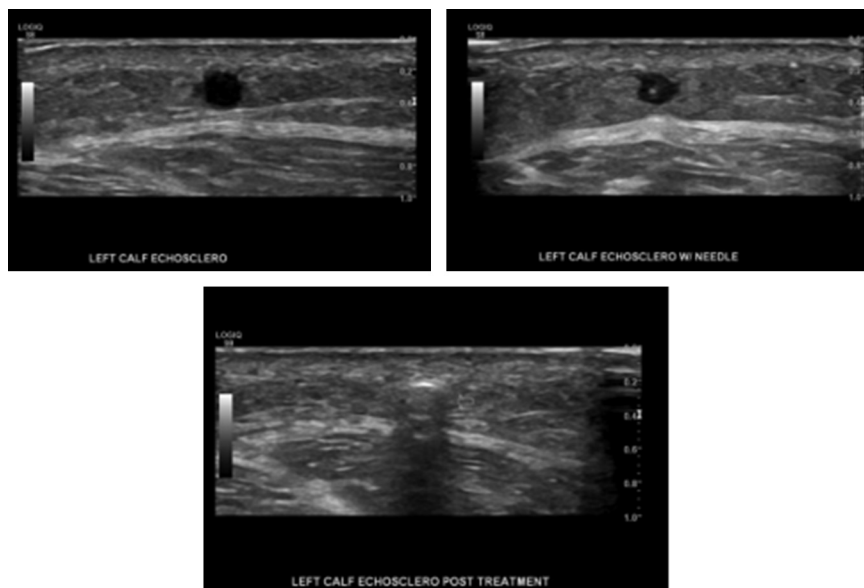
Ultrasound-guided foam sclerotherapy.
